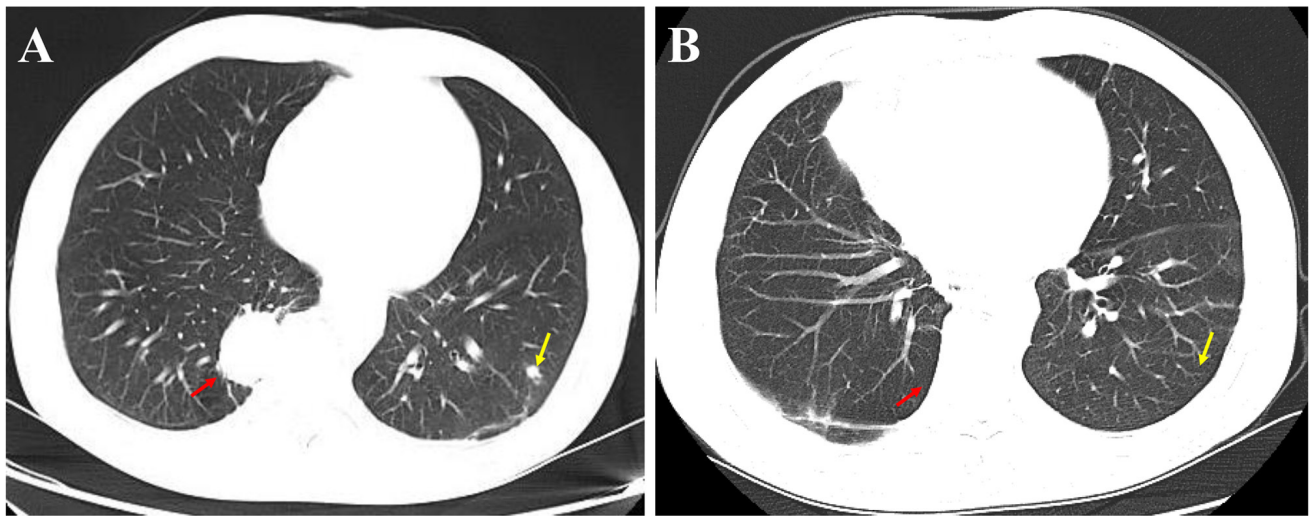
Contrast-enhanced CT before and after treatment. (A) The axial contrast-enhanced CT image shows an oval lesion in the right lower lobe (red arrow). Careful evaluation of the CT scan, including this image and the full series, did not definitively demonstrate a systemic arterial supply to the lesion. A nodule in the left lower lobe (yellow arrow) is also observed. (B) Follow-up contrast-enhanced CT scan after surgery shows the post-resection change in the right lower lobe (red arrow) and resolution of the left lower lobe nodule (yellow arrow).
